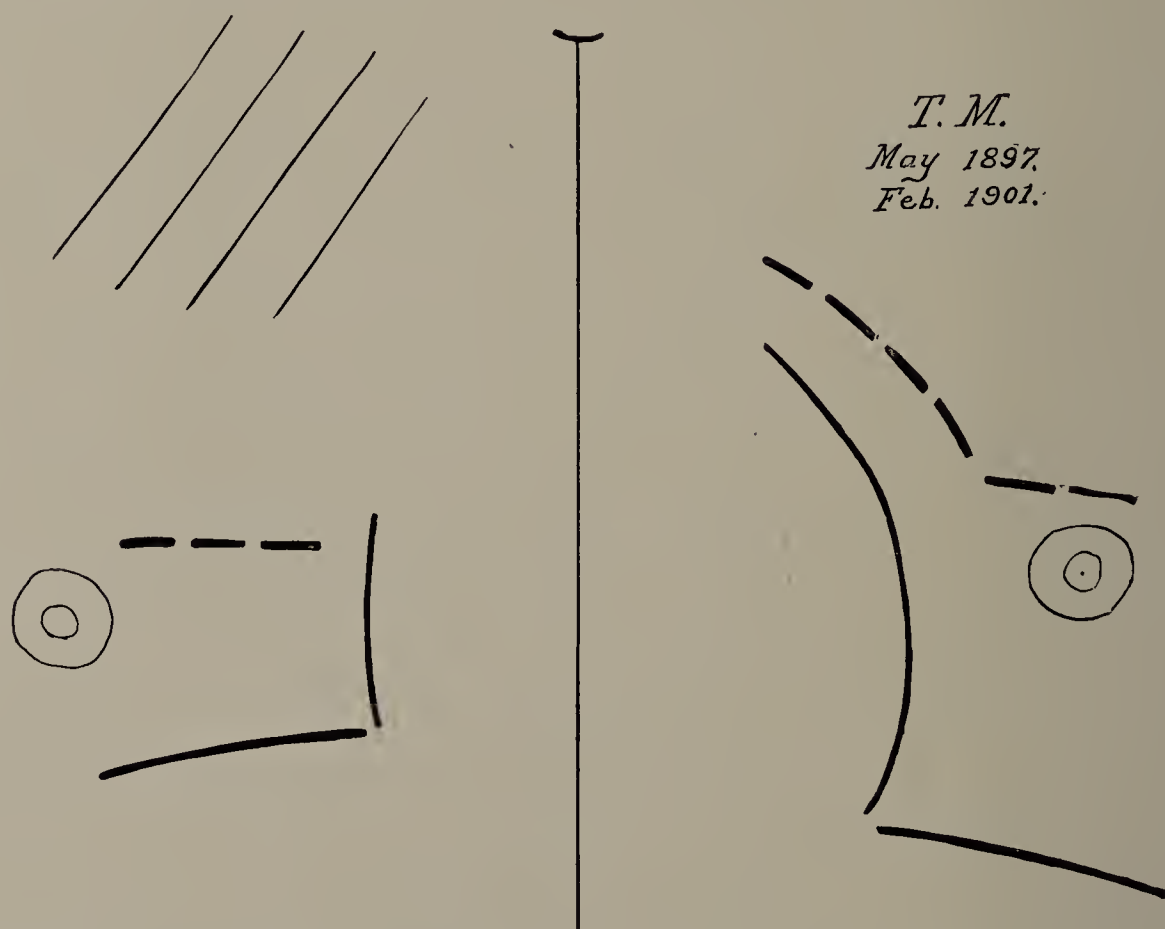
T. M. X-ray tracing (one-third life size). Right lung shaded; excursion of diaphragm on right side 4.5 centimetres; on left side 7.5 centimetres.
